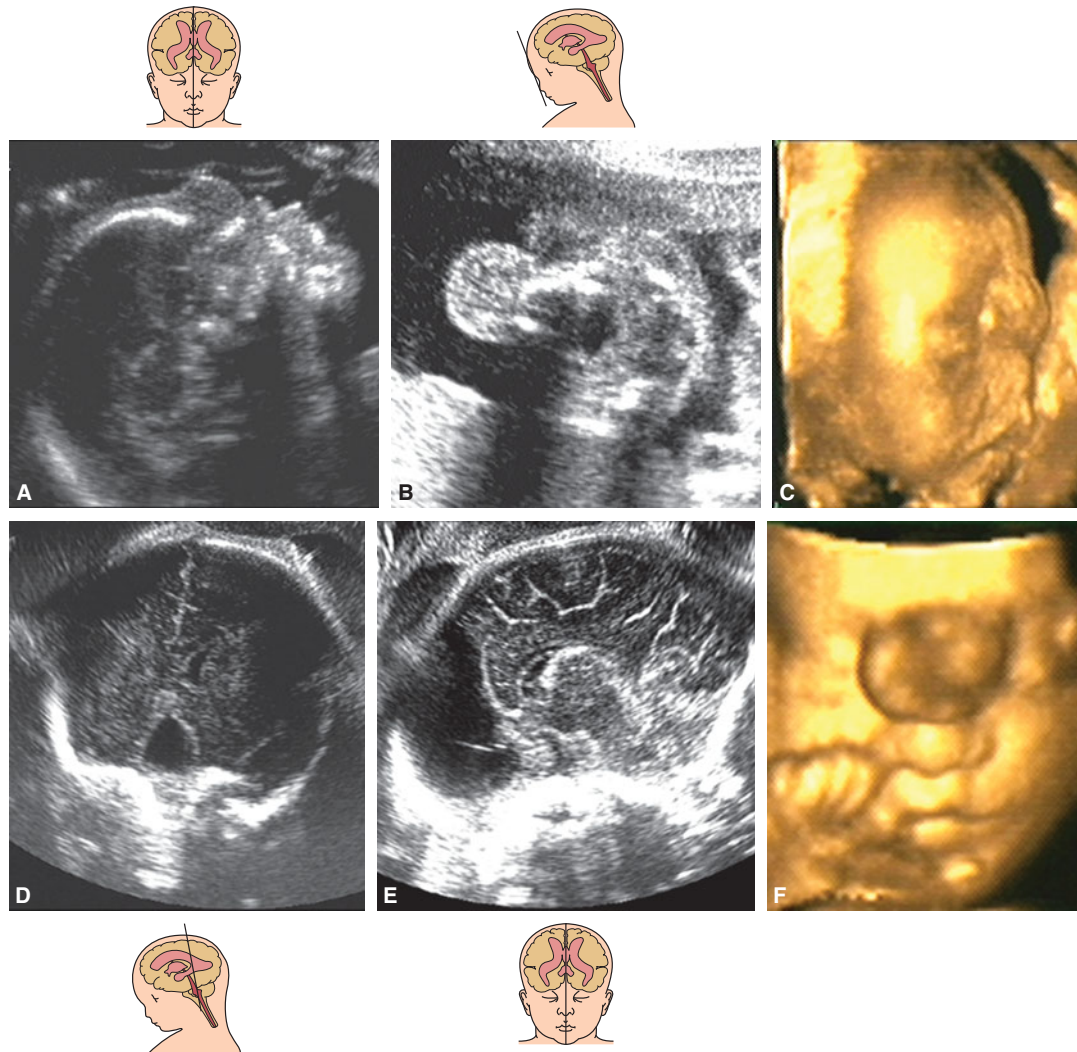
A fetus with an anterior encephalocele was scanned at 25 (A)–(C) and 32 (D), (E) postmenstrual weeks using 2D and 3D sonography. (A) The profile shows a mass superior to the nose and the nasal bone, as well as the skull defect. Although the brain is not clearly seen, it was normal. (B) Coronal section through the level of the anterior cephalocele. (C) The rendered face showing the mass. (D), (E) At 32 postmenstrual weeks in the anterior coronal and median section of the brain (E), a sonolucent space is seen; this is the result of the herniated brain into the cephalocele sac. (F) The rendered image of the fetus at 32 postmenstrual weeks.
